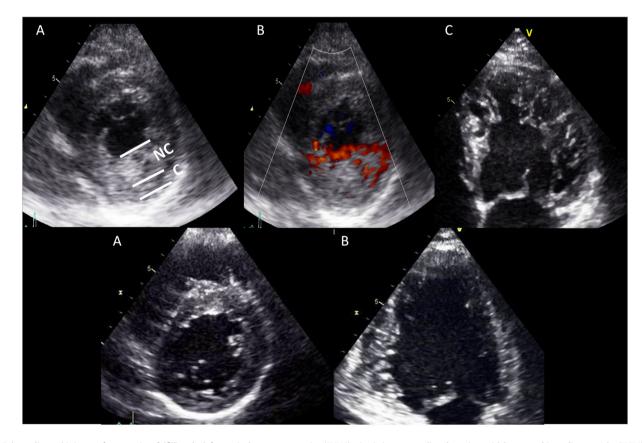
Echocardiographic images from a patient fulfilling the left ventricular non-compaction (LVNC) criteria (upper panel) and a patient with hypertrophic cardiomyopathy (HCM) (lower panel). Upper panel A. Image from parasternal short-axis showing thickened myocardium consisting of two layers: a thin compacted epicardial layer (C) and a thicker non (N)-compacted (C) endocardial layer. NC/C layer >2 at end-systole. Upper panel B. Trabecular recesses filled with blood from the left ventricular cavity. Panel C. Apical four-chamber view with predominant location of trabeculation in the LV lateral free wall segments. Lower panel A: Posterior wall trabeculations in parasternal short-axis view in a patient with HCM not fulfilling LVNC criteria. Lower panel B: Trabeculations in the inferior wall visible in two-chamber view.
